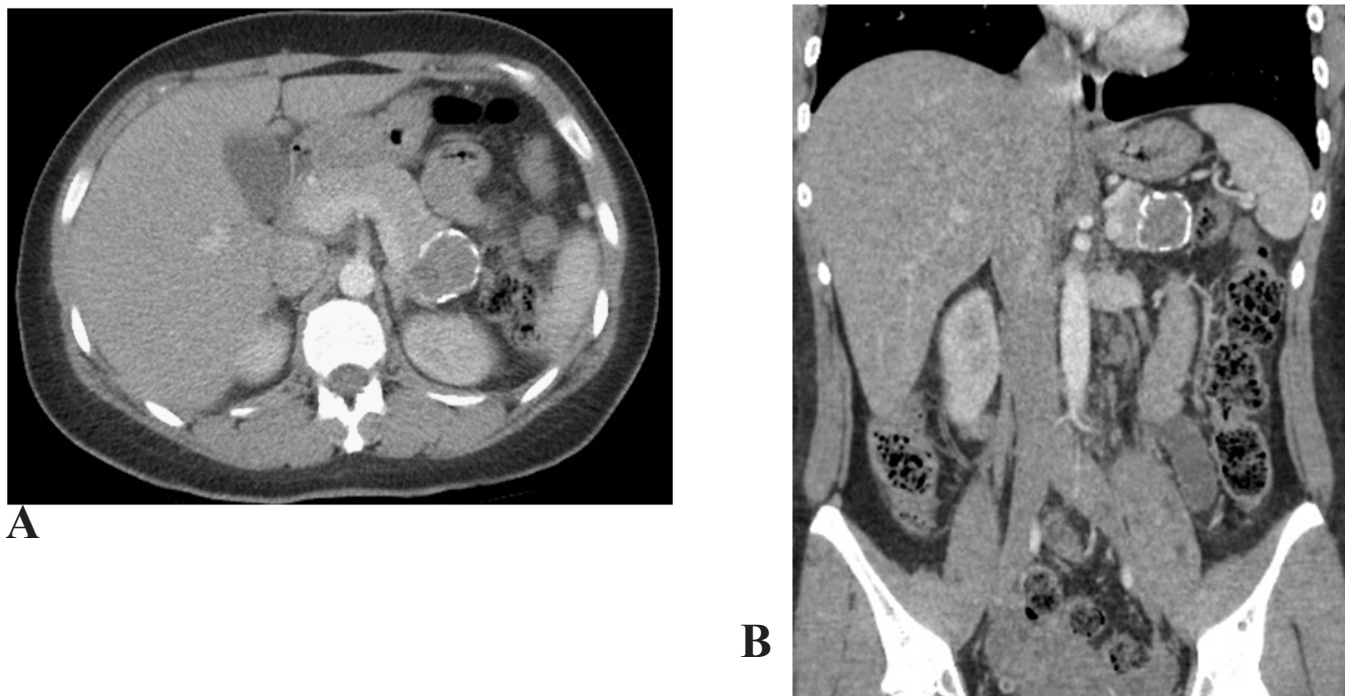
Computed Tomography of the abdomen and pelvis with contrast. (A) Axial and (B) Coronal projections revealed a 3.3 (AP) x 2.8 (TRV) x 3.3 cms hypodense, well defined, peripherally calcified lesion at the pancreatic tail. (arrows). Finding were consisted with a biopsy proven diagnosis of Solid Pseudopapillary Neoplasm of the Pancreas.
